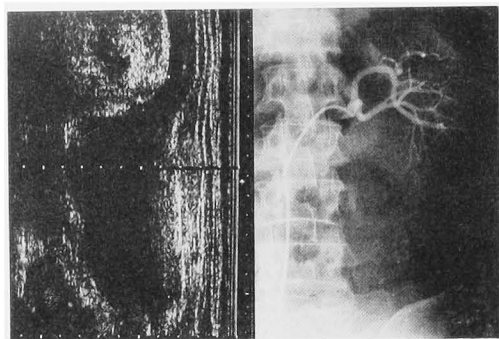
Left: Preoperative sonography indicates, on the ventral side of the lower pole of the left kidney, an echogenic mass having a partially transsonic area at its center as well as a transsonic area extending from the circumference of the tumor to the iliac crest. Right: Selective renal arteriography shows a tortuous coarse, feeding vessels at the area corresponding to the lesion of the lower pole, but there is no indicating bleeding.
